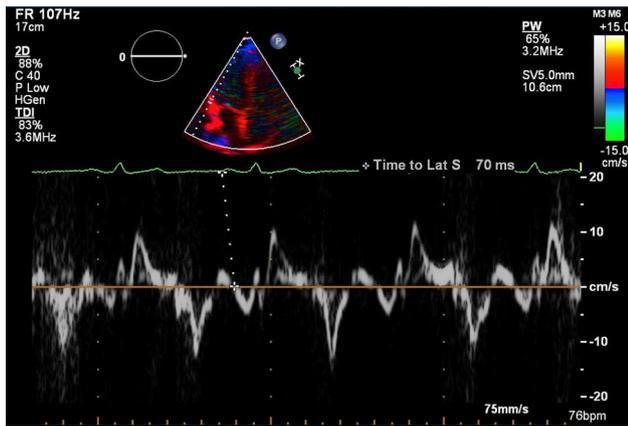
The evaluation of atrial conduction times by means of Doppler echocardiography
